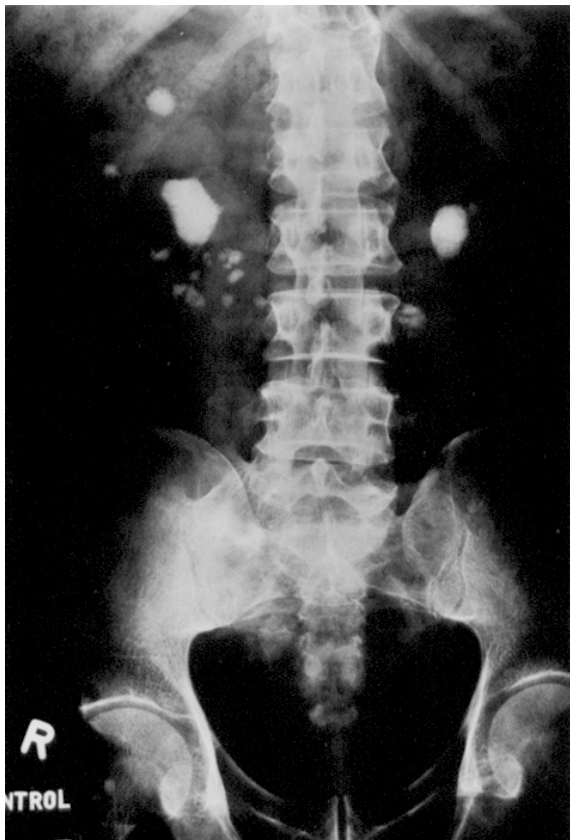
Control radiograph.
